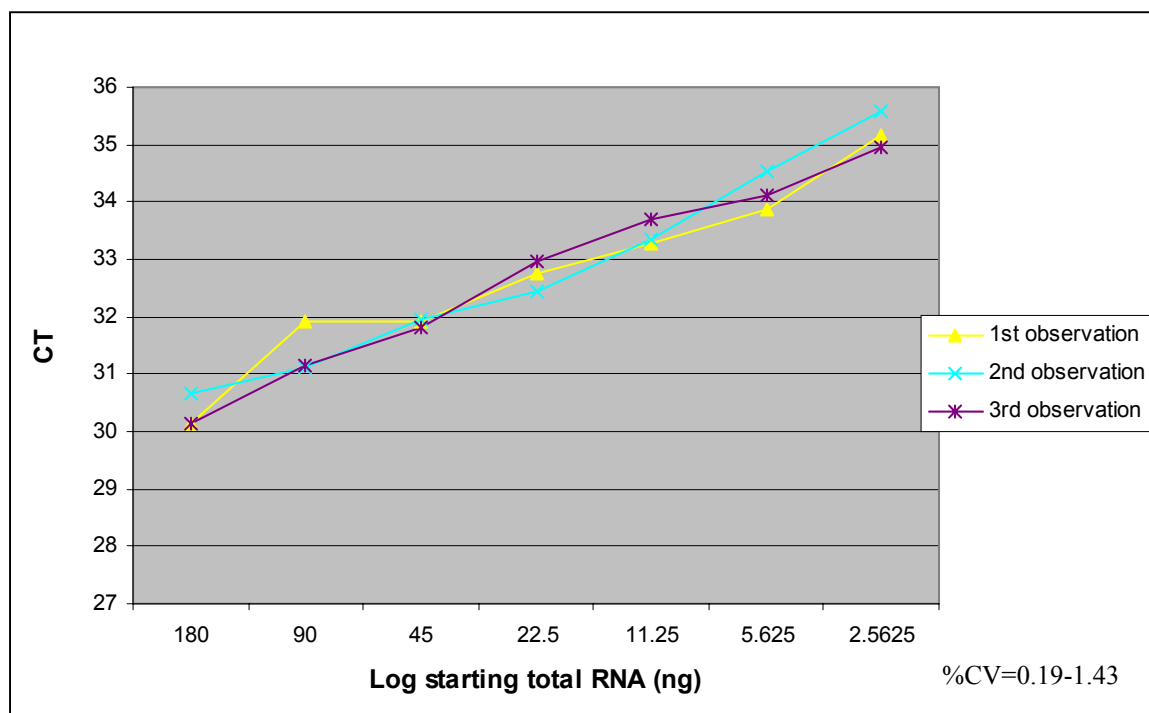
Plot of CT numbers from each observation and log starting total RNA (ng) of TaqMan® CYP1A1 PCR
